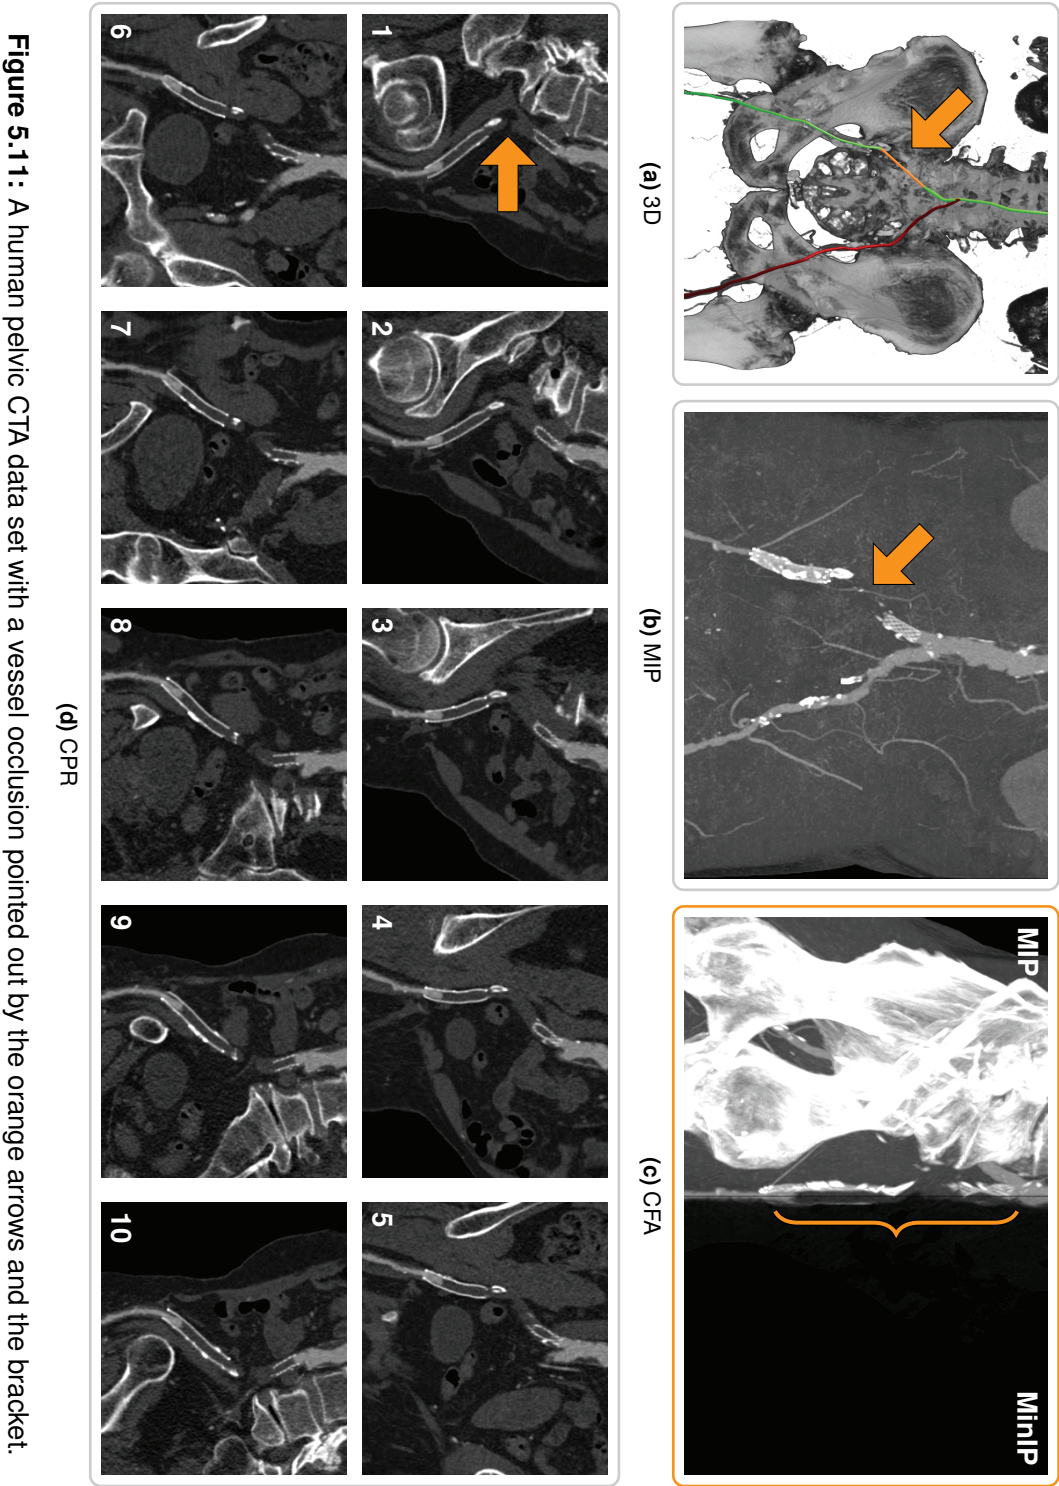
A CTA data set of the human pelvis with a vessel stenosis pointed out by the orange arrows.
